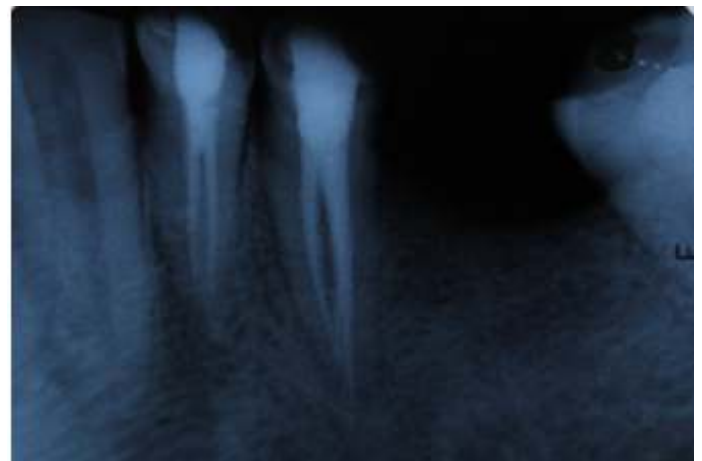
Periapical radiograph after six months.
